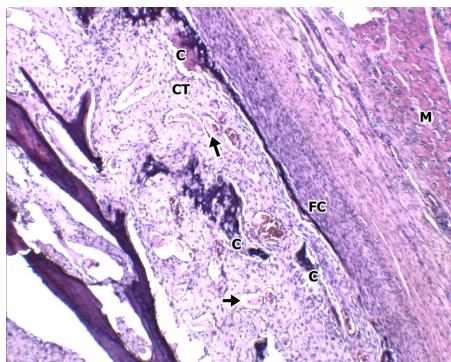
Remnants of teeth with calcification (C) (bluish-purple), loose connective tissue (CT) and capillaries (arrows), fibrous capsule (FC) and muscle bundles (M) (outer side), $\times 40$, H/E.
